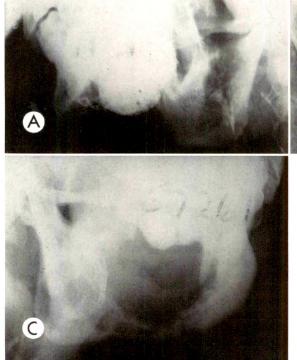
(A) Roentgenogram of patient with barium impregnated betel quid located in the buccogingival sulcus. Compare the location with that in B and C, roentgenograms of patients with progressively greater bone destruction by tumor. The early cases appear to have more sharply defined excavations compared to the more "moth-eaten" involvement of the cases with pathologic fracture.
